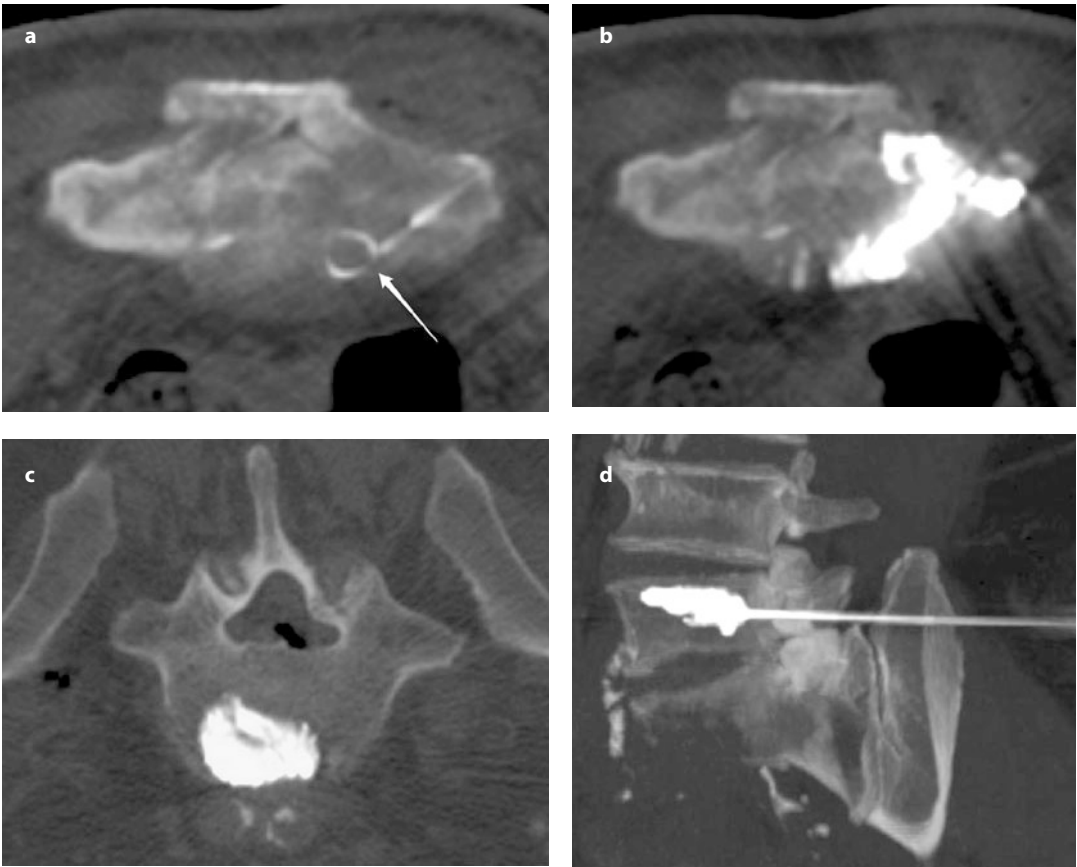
Axial CT slice showing a spring-shaped electrode inside a left sacral wing metastasis (a) followed by cement augmentation (b). Axial CT slice (c) and transparent volume-rendering (d) of a L5 somatic metastasis ablated by radiofrequency and then augmented
